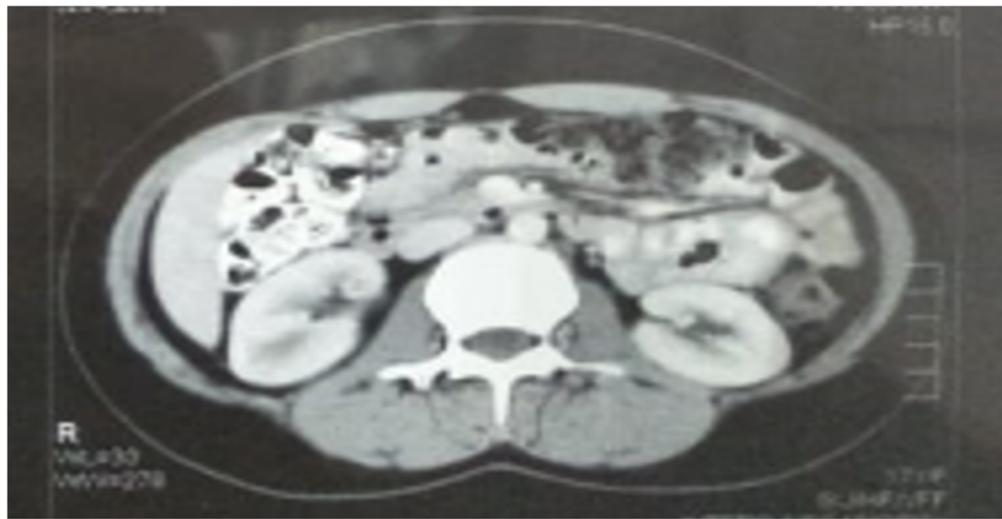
Computed tomography axial view showed minimal fullness of left pelvicalyceal system.
